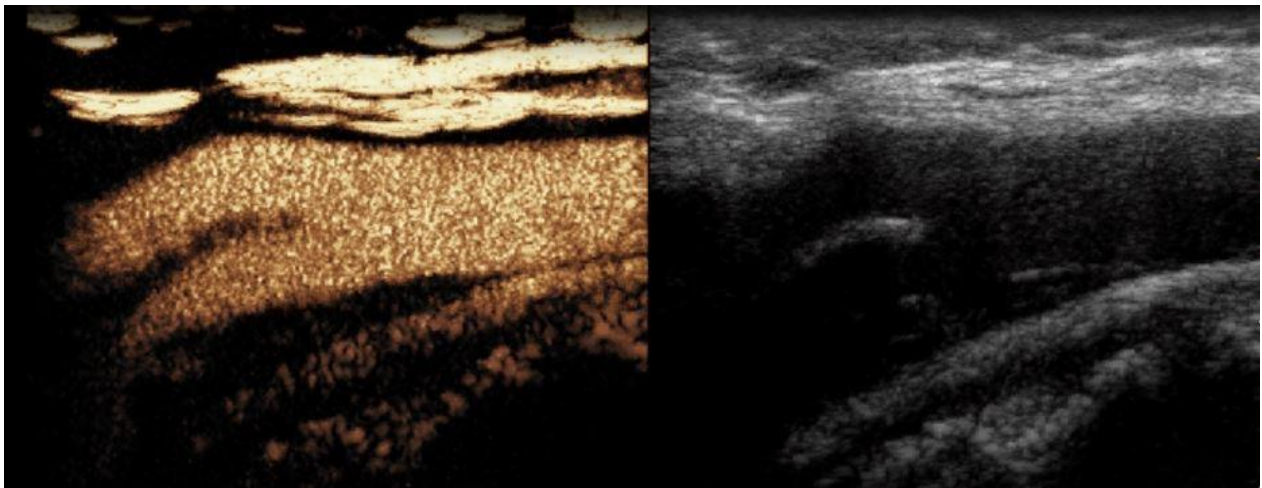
Simultaneous side-by-side CEUS (left) and B-mode (right) imaging, acquired using a radiology (rather than cardiology) ultrasound system [Philips iu22]. *Image courtesy of Dr Mengxing Tang, Imperial College, London.*
